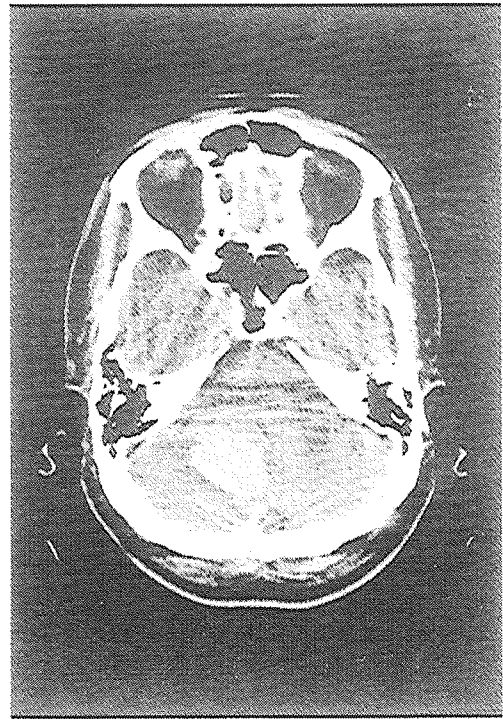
Brain CT scan in patient 1 reveals intracerebellar hemorrhage in episode 1.
